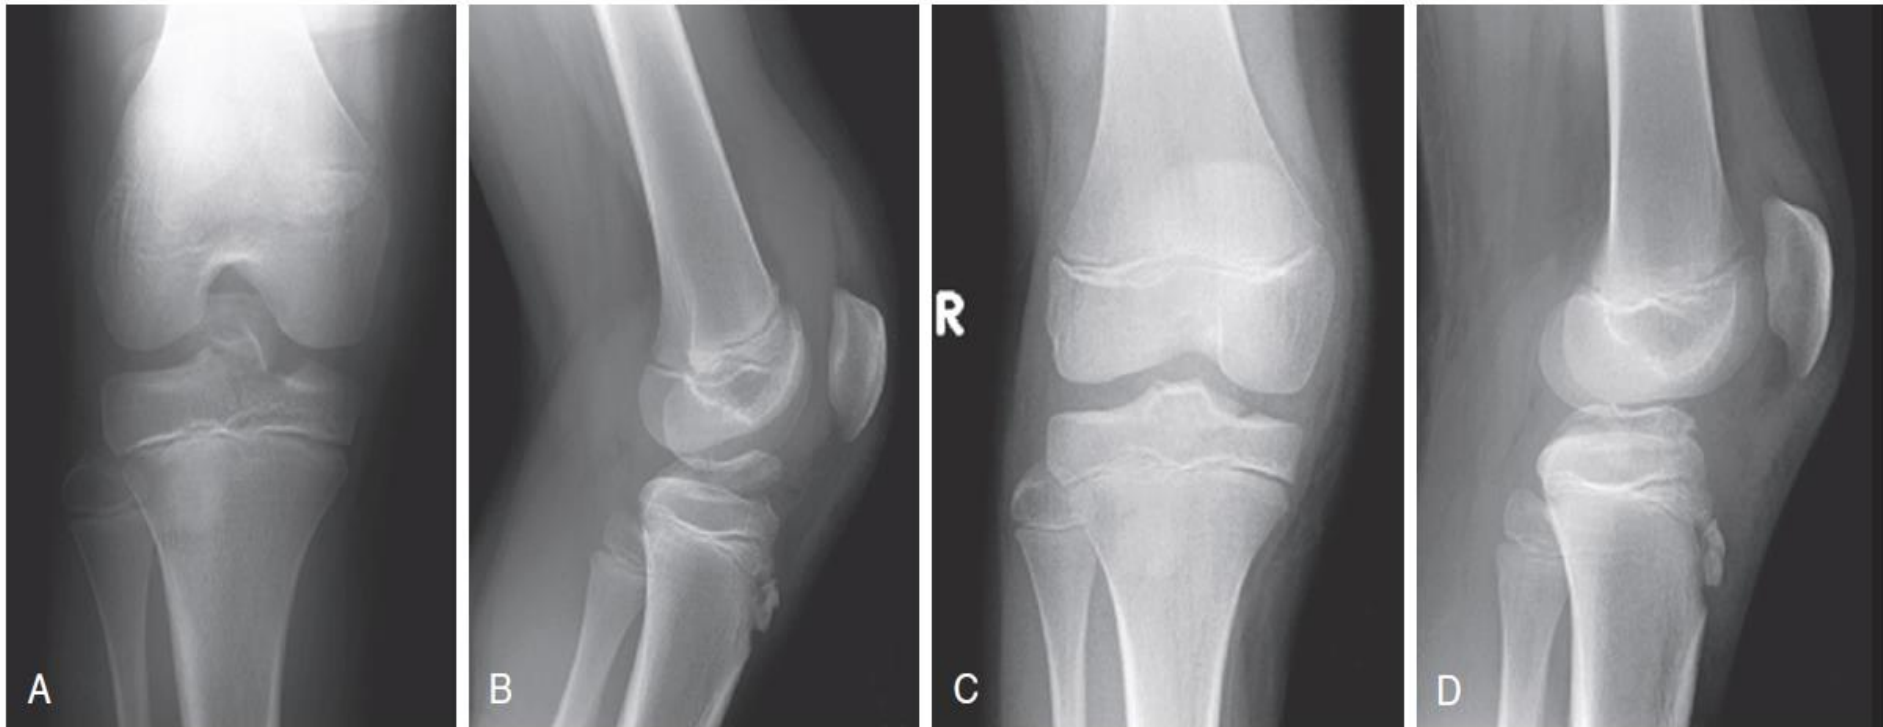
Type 2 Tibial Spine Fracture Treated With Arthroscopic Reduction and Suture Fixation. (A) Preoperative anteroposterior radiograph. (B) Preoperative lateral radiograph. (C) Postoperative anteroposterior radiograph. (D) Postoperative lateral radiograph.
